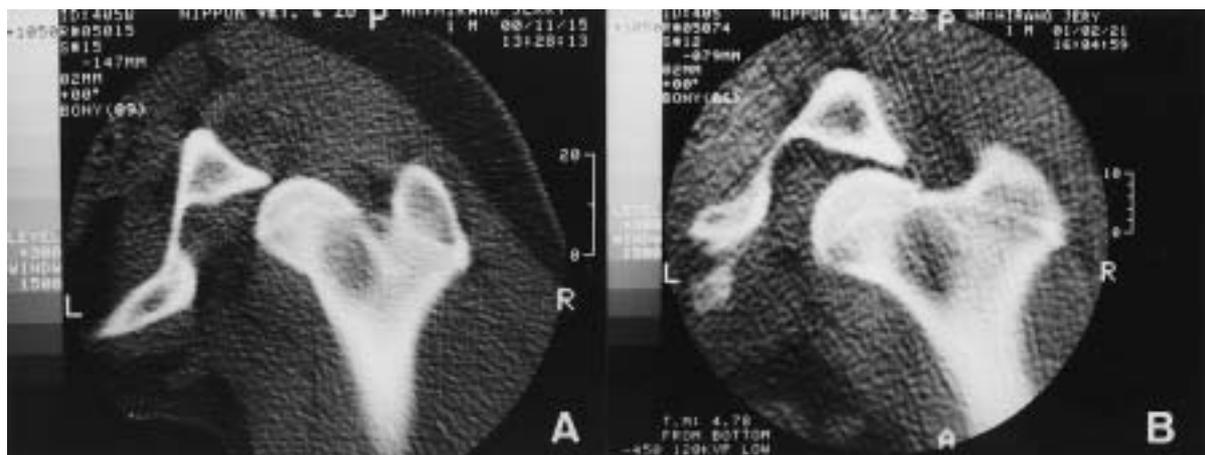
Pre- and postoperative computed tomographic images of Case No. 7. A: Preoperative transverse computed tomographic image. B: Postoperative transverse computed tomographic image. The femoral head coverage by the acetabulum, reflecting the load-bearing area of the articular surface, was significantly improved after surgery.
